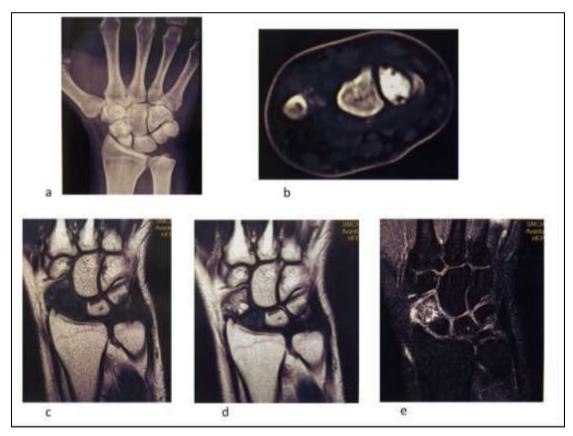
Osteonecrosis of Scaphoid. X ray (a), CT (b), MRI T1 Coronal (c), T2 Coronal (d) and Post-contrast Coronal (e).
